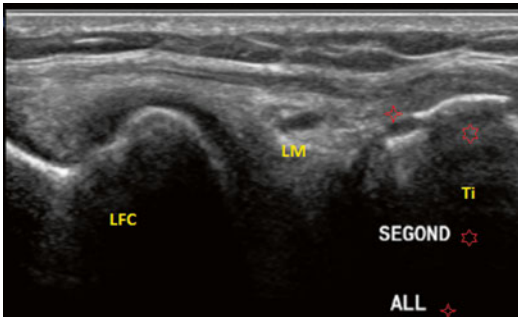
Ultrasound detection of an acute Segond lesion in combined knee injury
